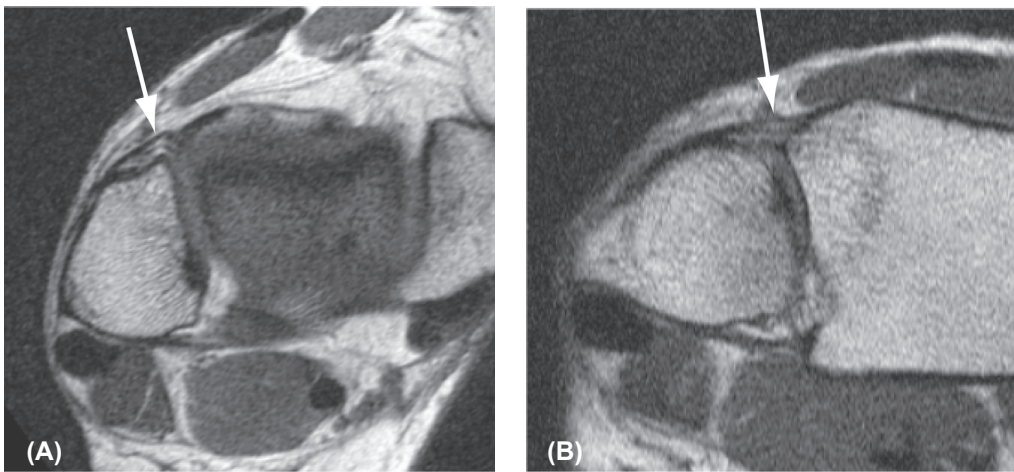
Axial (A) and oblique (B) T1-weighted TSE image of the ATIFL (arrow) in a healthy volunteer. The ATIFL has a wavy aspect on the axial image (A) and a straight aspect on the oblique image (B). The continuity and multifascicular aspect of the ATIFL are better demonstrated on the oblique image. A wavy aspect of the ATIFL can thus not be used as a parameter for injury of the ATIFL, in an axial scan plane.
